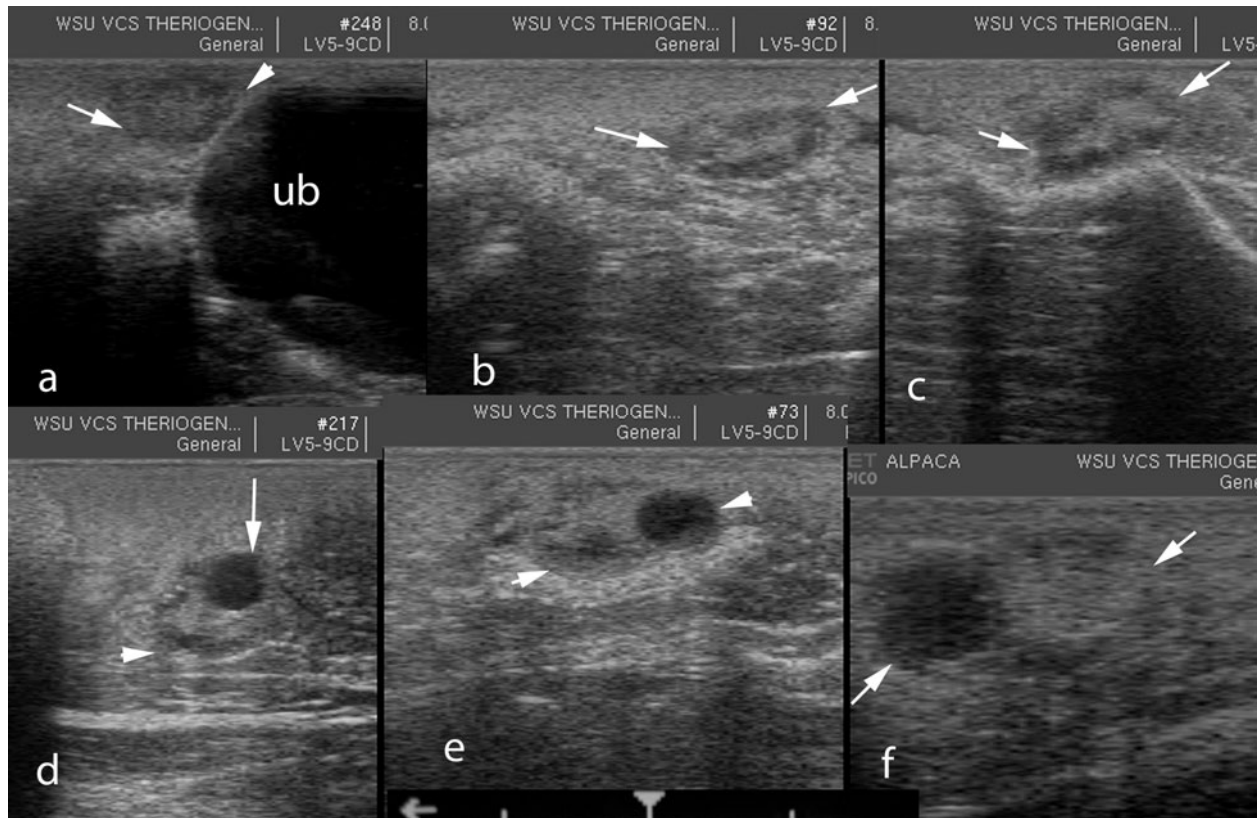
Ultrasonographic imaging of follicular dynamics in camelids. a) Quiescent ovary (arrows), ub= urinary bladder, b) and c) Follicular recruitment, d) Follicular dominance, e) Mature follicle, f) Regressing follicle. Note the hyperechoic ovarian stroma and the more hypoechogenic cortex.
